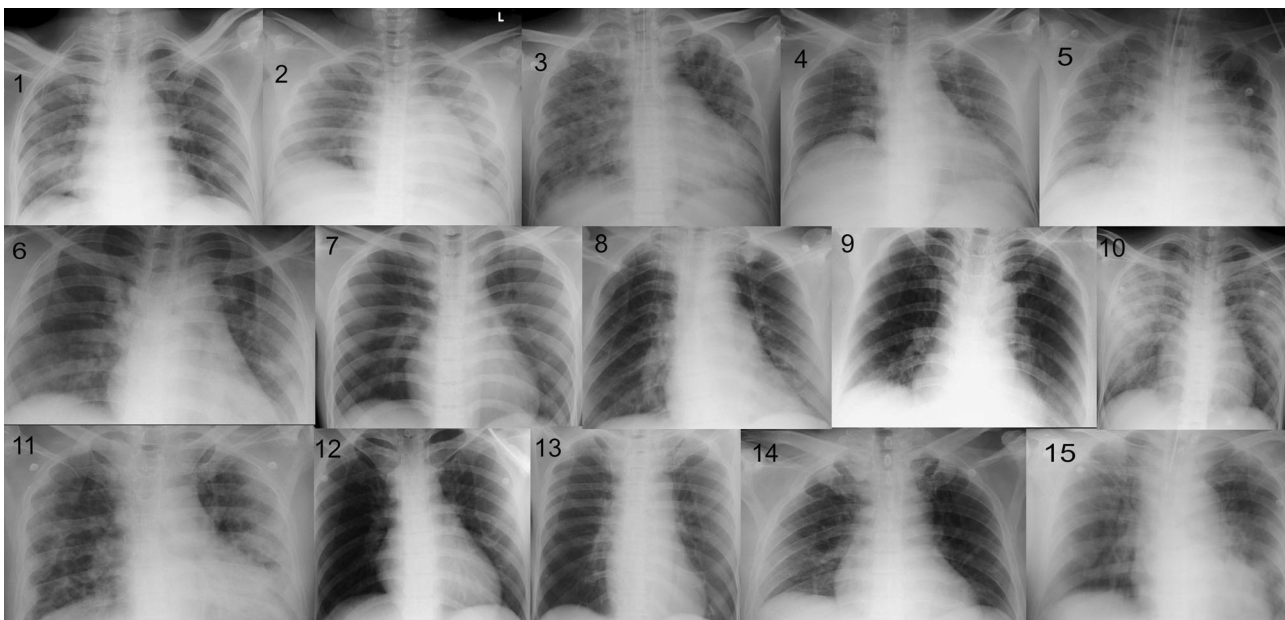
Chest X-ray findings in patients with COVID-19 and leptospirosis coinfection. 1—ill-defined opacity in the right lower zone, 2—ill-defined opacity in the left lung field, 3—ill-defined opacities in bilateral lung fields, 4—homogeneous opacities in left lung field, 5—perihilar opacities in both lung fields, 6—reticular opacities in bilateral lower zones, 7—ill-defined opacities in the left lung field, 8—ill-defined opacity in the left lower zone, 9—reticular opacities in bilateral lower zones, 10—peripheral opacities in bilateral lung fields, 11—reticular opacities in bilateral mid and lower zones, 12—ill-defined opacity in the left middle zone, 13—ill-defined opacity in the left middle and lower zones, 14—ill-defined opacity in the left middle and lower zones, and 15—ill-defined opacities in the left lower zone.
